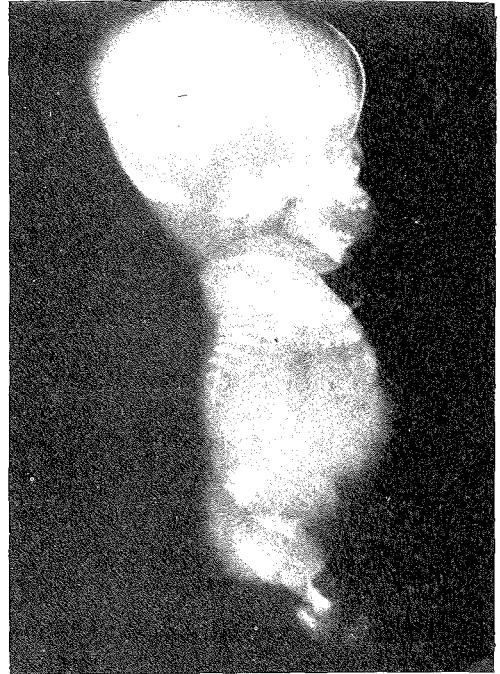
Achondrogenesis: anterior and lateral radiographs showing non-ossification of vertebrae and pelvic bones; small ilia with concave inner and inferior margins; small thorax with short ribs; prominent abdomen and large head with normal ossification of skull. The tubular bones of the limbs are short and show characteristic metaphyseal widening and cupping.
